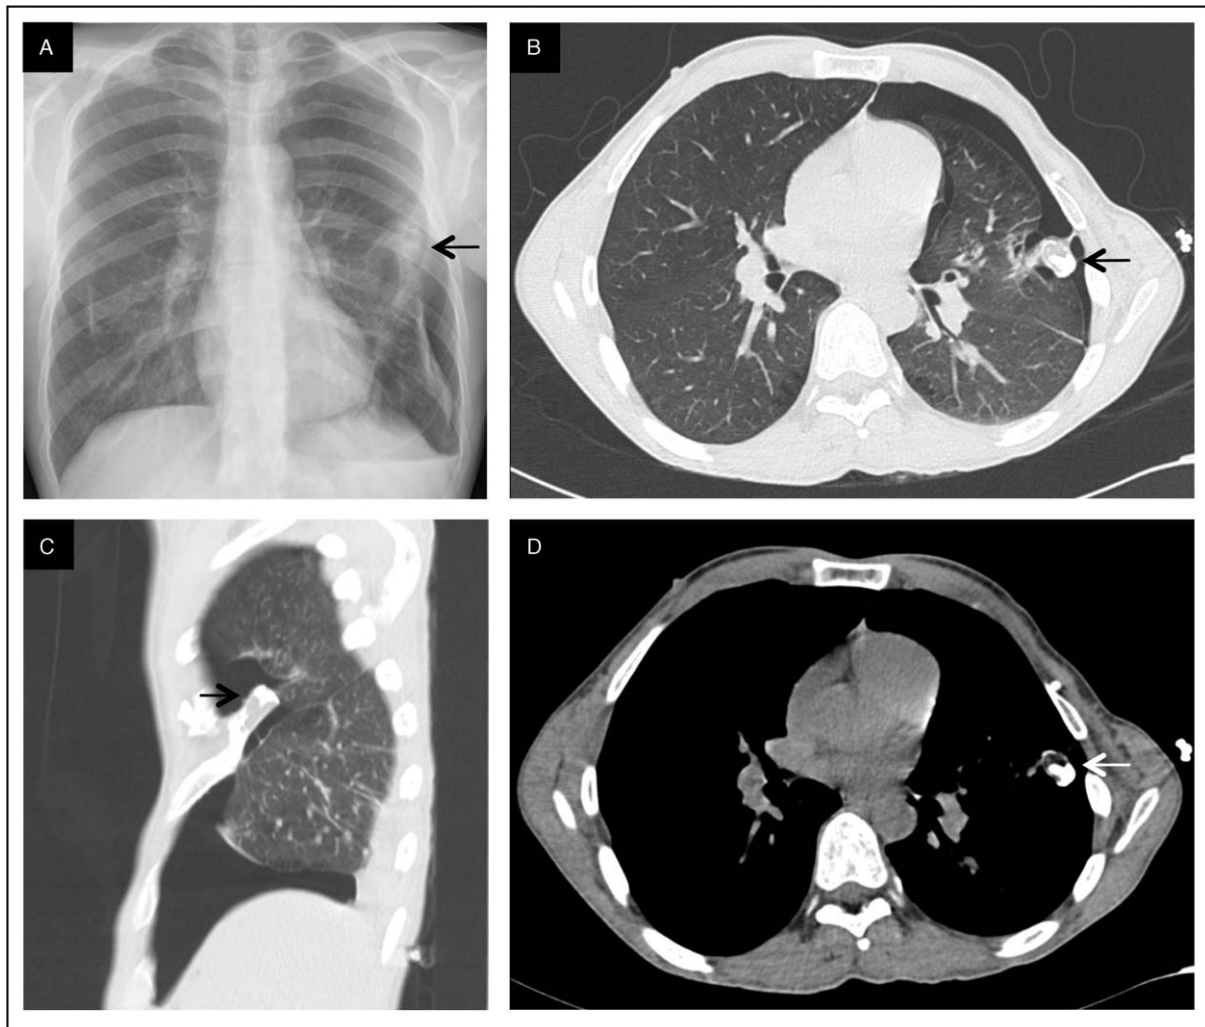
A, Chest X-ray showing left pneumothorax. B–D, Chest CT scan showing left pneumothorax, peripheral emphysema and rib exostosis.
